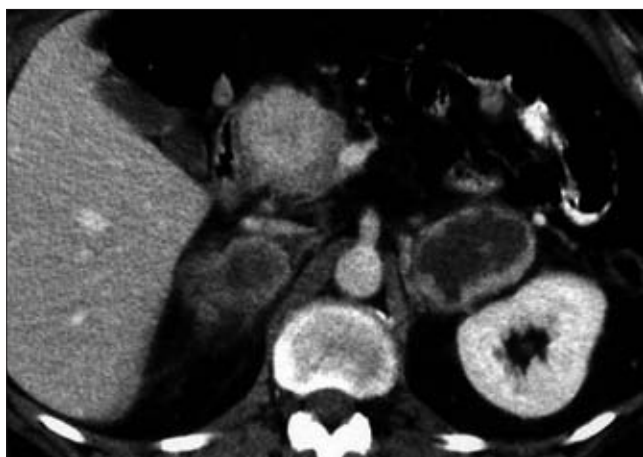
A homogeneously enhancing solitary metastasis in the head of the pancreas is visible on CT of a 52-year-old patient with squamous cell lung carcinoma and bilateral adrenal metastases.
